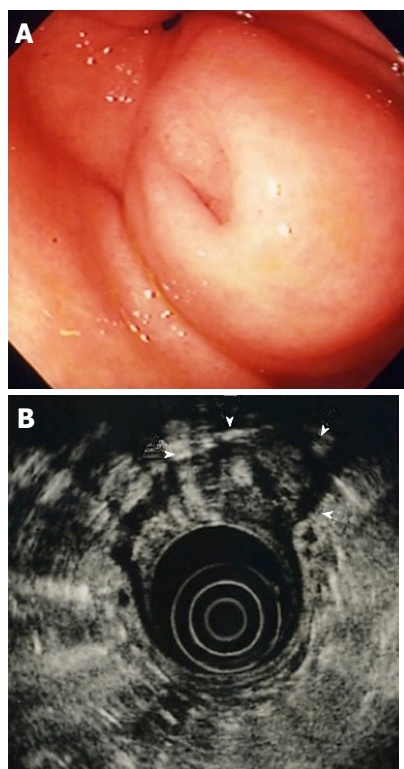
Esophagogastroduodenoscopic and endoscopic ultrasonographic images of submucosal lesion at the first examination. A: Esophagogastroduodenoscopy. Submucosal lesion was visible in the antrum of the stomach; B: Endoscopic ultrasonography. Lesion (arrow heads) located in the third layer (submucosa) with a diameter of 20 mm, slightly hypoechoic internal echo, and anechoic lumen, regarded as the duct.
